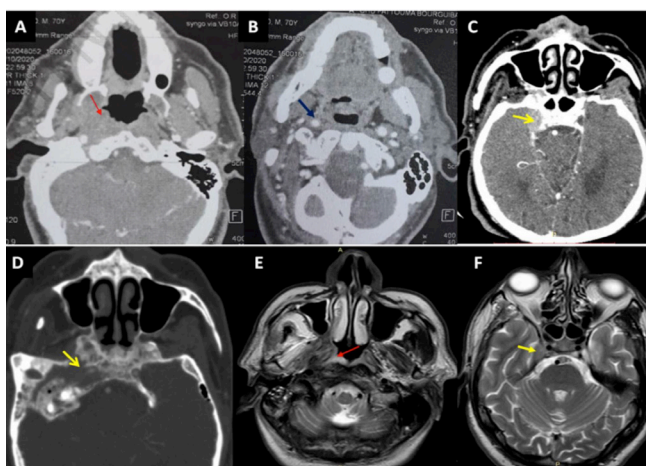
CT (A, B, C, D) of the facial mass in the parenchymal window after injection of contrast product (A, B, C) and bone window (D) and MRI of the facial mass in T2 sequence fat sat (F, E) passing through the cavum showing on axial sections a tumor process of the upper and right lateral wall of the nasopharynx filling the fossa of Rosen Müller and obstructing the eustachian tube on the right (red arrow) with extension in lateral to the FIT medial and lateral pterygoid muscle invasion (red star). We noted an invasion of the lacerum and ovale foramen and of the right cavernous sinus (arrow yellow) and a sheath of the carotid in its intra petrous and intracavernous portions (blue arrow).
